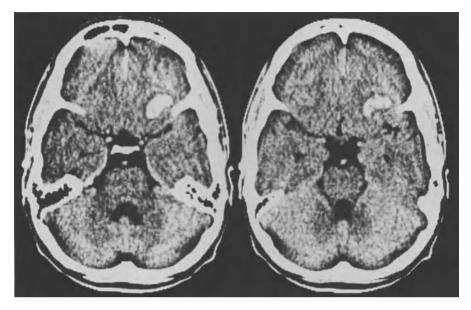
Unenhanced CT scan of 15-year-old girl who had fainted before admission to the hospital and was neurologically normal at that point except for a slight headache
